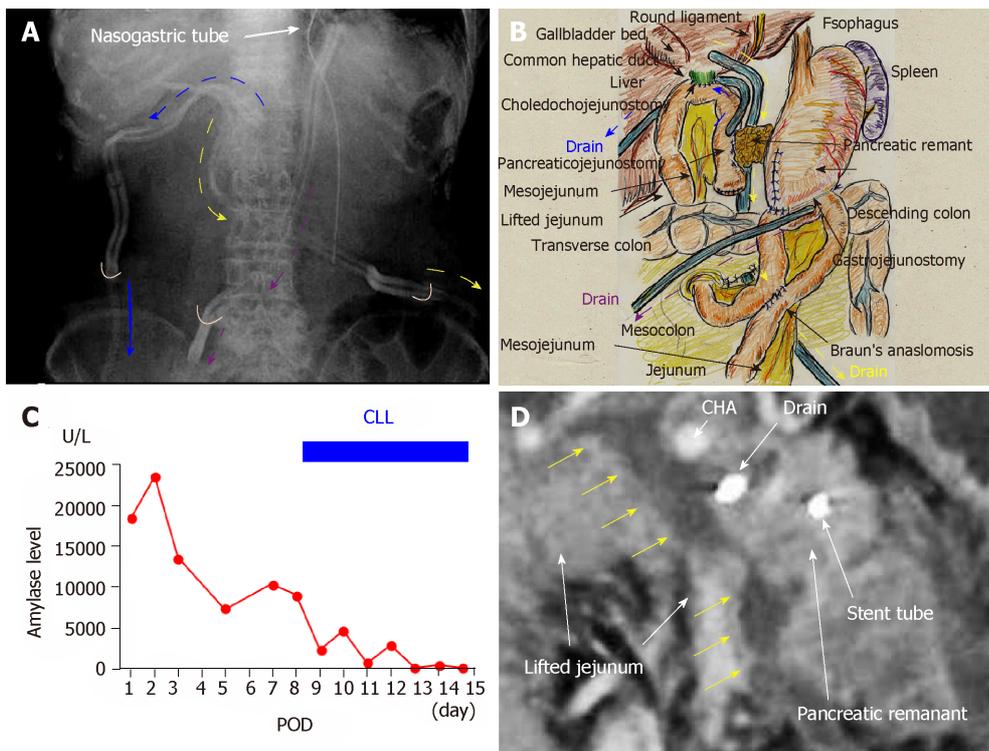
Case 1. A and B: We placed three drains near the anastomoses of the pancreaticojejunostomy (yellow arrows), choledochojejunostomy (blue arrows), and gastrojejunostomy (purple arrows). For the pancreaticojejunostomy, we ran two drains intentionally through the ventral and dorsal sides (yellow and blue arrows, respectively); C: Pancreatic leakage began early postoperatively, and peak amylase level in the drainage discharge was 23480 U/L. High amylase levels in the drainage discharge were still seen on postoperative day (POD) 8 continuous local lavage (CLL) was initiated on POD 8, and saline volume was increased on POD 12. We continued CLL for 7 d, and amylase levels in the drainage discharge decreased dramatically during that time; D: Contrast computed tomography on POD 8 revealed intractable pancreatic fistula had led to an intraperitoneal abscess around the pancreaticojejunostomy (yellow arrows). CHA: Common hepatic artery; CLL: Continuous local lavage; POD: Postoperative day.
